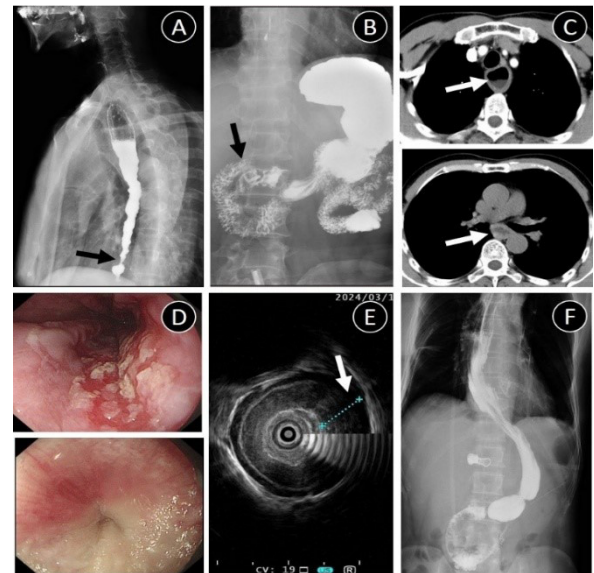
Patient's barium meal fluoroscopy, CT, and gastroscopy results. (A) Pre-operative barium meal fluoroscopy shows distal esophageal spasm (black arrow) and proximal esophageal dilation; (B) Barium meal fluoroscopy shows barium entering the small intestine after 4 minutes (black arrow); (C) CT shows proximal esophageal dilation and distal esophageal lumen narrowing (white arrow); (D) Gastroscopy shows opaque white changes in the esophageal mucosa, and distal esophageal narrowing; (E) Endoscopic ultrasound shows thickening of the esophageal wall (white arrow); (F) Post-operative barium meal fluoroscopy shows normal anastomosis with no esophageal spasm.
